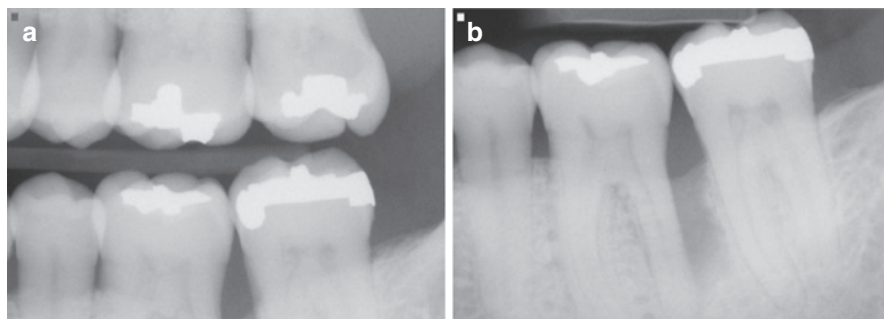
Tooth #19 is an example of a minimally restored tooth with no obvious explanation for a diagnosis of pulp necrosis and deep vertical periodontal defect on the distal. (a) The patient acknowledged bruxism and a long history of intermittent biting stress sensitivity on the mandibular left side. Approximately 2 years prior to these radiographs, the problem was initially diagnosed as an isolated periodontal defect and treated with surgical pocket debridement, deep scaling, and bone graft/GTR. (b) Since the true source of the lesion was pulp necrosis secondary to incomplete vertical root fracture, the lesion recurred. Note also the appearance of diffuse calcifications in the pulp chamber, which is suggestive of long-term low grade chronic inflammation occurring prior to pulp necrosis
